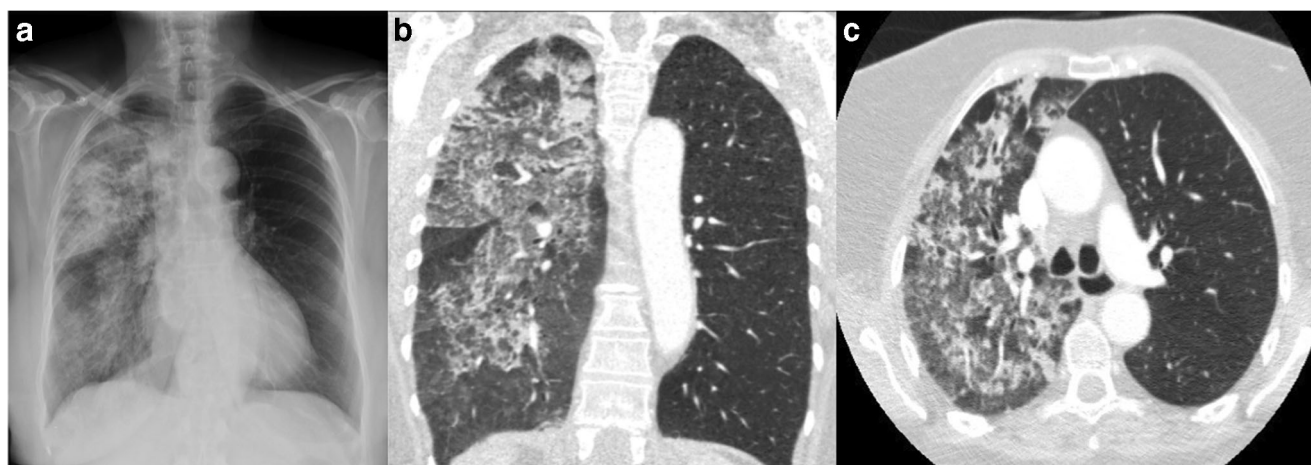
Alveolar infiltrates on chest X-ray (a) and ground-glass opacities on high-resolution computed tomography (b, c) sparing the left hemithorax due to a complete unilateral right-sided diffuse alveolar hemorrhage in granulomatosis with polyangiitis
